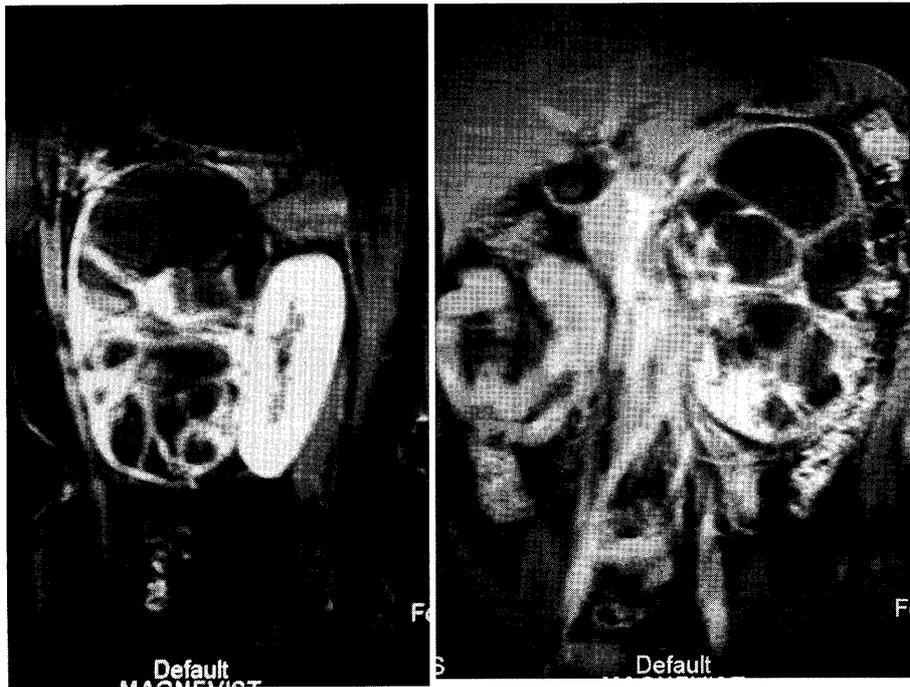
MRI image showing a large retroperitoneal mass with solid and cystic components
